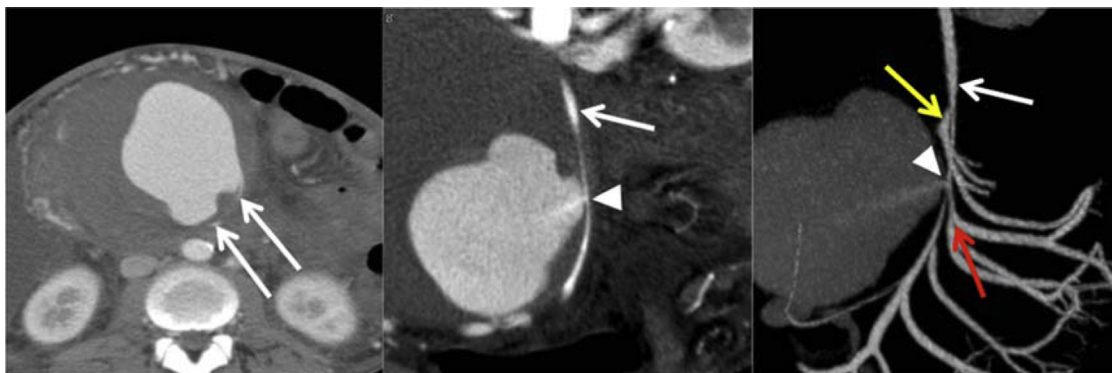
Abdominal contrast-enhanced computed tomography (CE-CT) scans and maximum intensity projection showed a pancreatic pseudoaneurysm measuring 13 × 12 cm in diameter that originated from the superior mesenteric artery (SMA; *white arrow*) trunk. The SMA was excluded and extended from the pancreatic head to the porta hepatis. *Arrowhead*, Pseudoaneurysmal neck; *yellow arrow*, first jejunal artery; *red arrow*, second jejunal artery.
